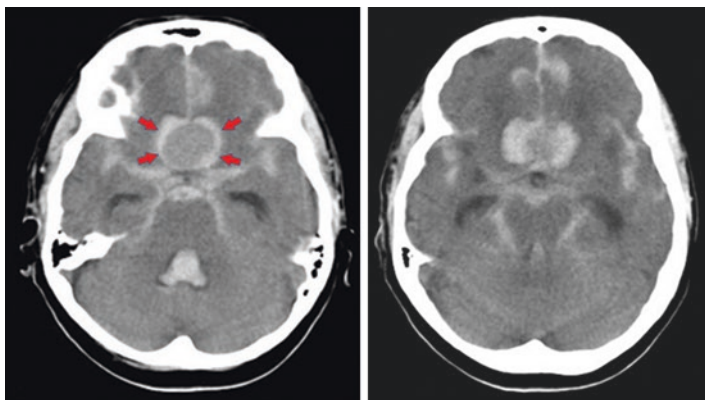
Brain CT scan showing a giant anterior communicating artery aneurysm. Note the widespread SAH and hydrocephalus. The outline of the aneurysm is made obvious by the blood surrounding the aneurysm wall in the interhemispheric fissure (red arrows)
